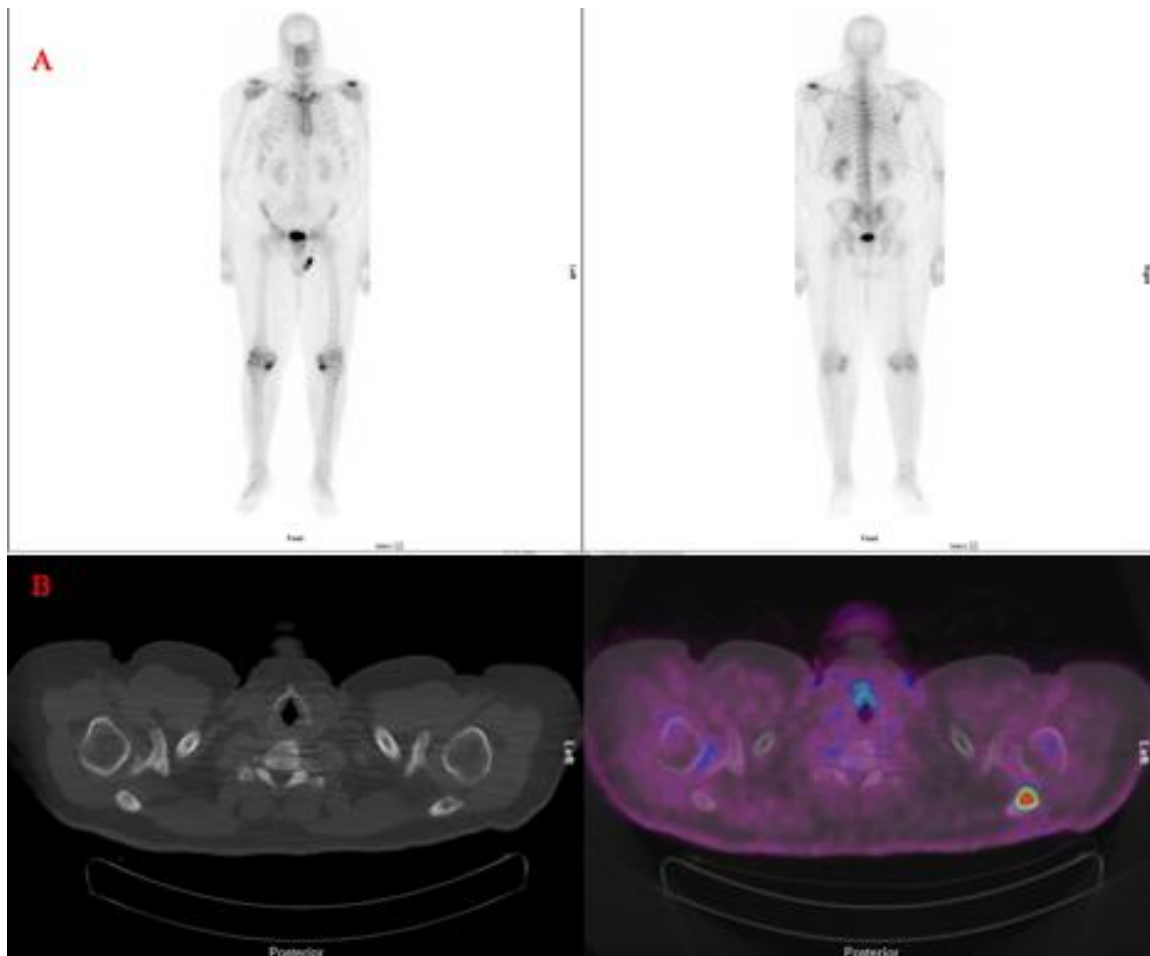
Bone scintigraphy and 18F-FDG PET/CT images of a 61-year-old man with newly diagnosed right breast adenocarcinoma. (A) Whole body planar images show symmetric degenerative joint disease uptake in multiple joints, including knees and sternoclavicular joints. The anterior view shows only subtle left > right shoulder uptake, while the posterior projection clearly demonstrates isolated increased uptake on the left shoulder. (B) Axial low-dose CT and fused PET/CT images at the level of the shoulders revealed a lucency in the left acromion with intense FDG uptake.
